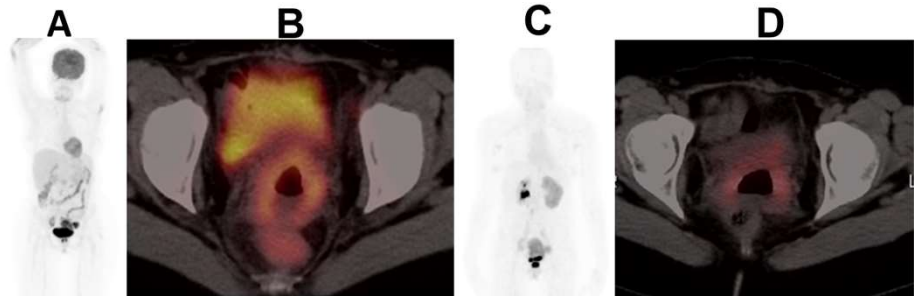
FDG PET(A and B) rectal uptake is noted. This is equivocal and may be inflammatory or local/rectal cervical cancer invasion whereas FAPi(C and D) demonstrates rectal sparing and may be useful in ruling-out local/rectal invasion.
